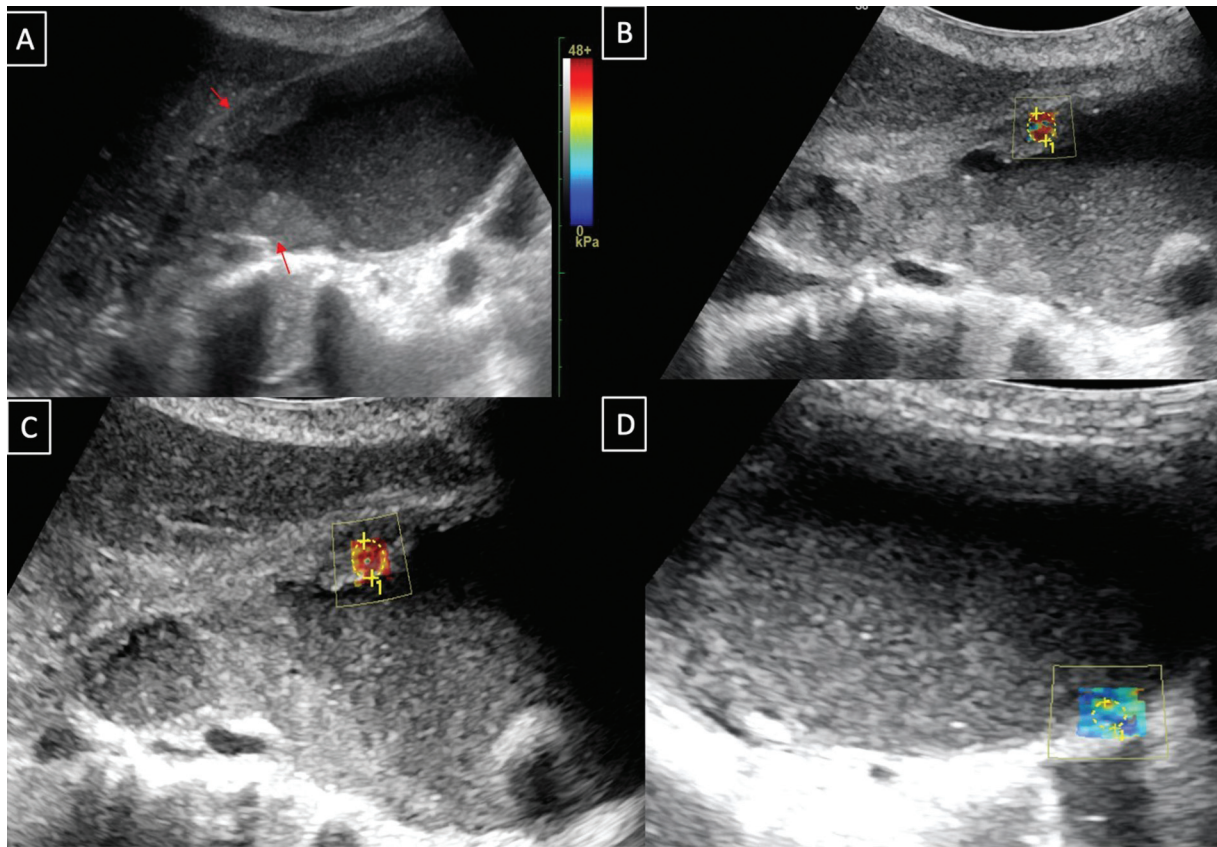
Transabdominal ultrasound grayscale image (A) of a 56-year-old female with malignant gallbladder wall thickening involving the body and neck region (arrow). There were significantly elevated elastography values in the involved wall (43.85–43.98 kPa) (B, C) as compared to the uninvolved wall (6.78 kPa) (D).
